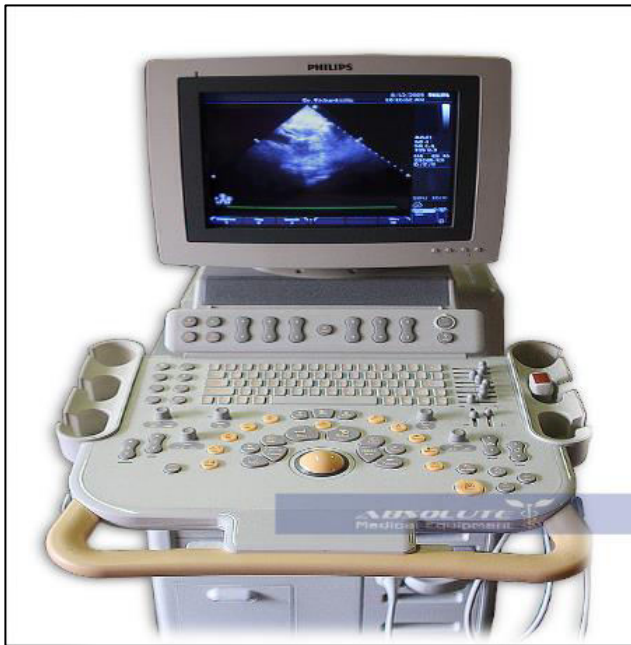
The ultrasound machine.
